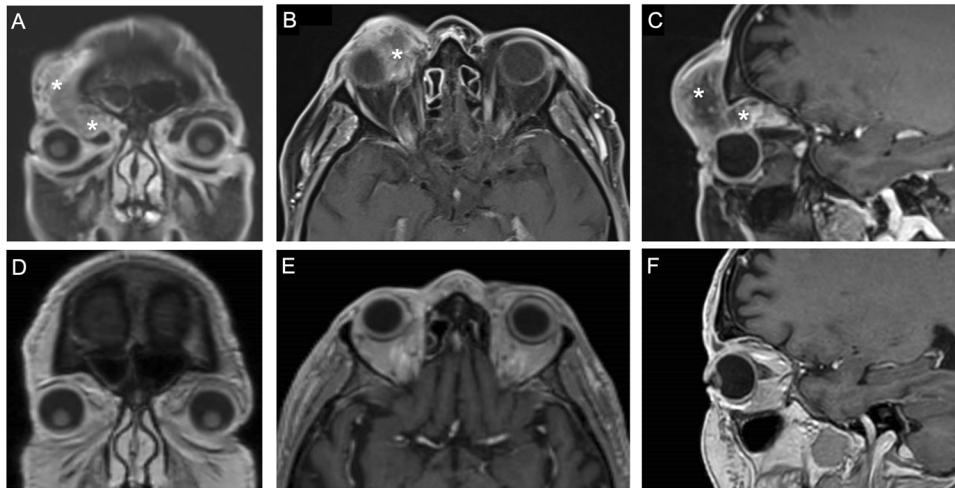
MRI scans of an 82-year-old man with squamous cell carcinoma with orbital involvement. A Before treatment; post-contrast coronal T1 fat-saturated image showing an ill-defined low enhancing mass penetrating the right orbit with globe compression. B Before treatment; post-contrast axial T1 fat-saturated image showing an ill-defined low enhancing mass penetrating the right orbit. C Before treatment; post-contrast sagittal T1 fat-saturated image showing an ill-defined low enhancing mass extending from the right forehead to the left orbit, advancing along the orbital and penetrating the right orbit. D After treatment; post-contrast coronal T1 image showing a complete response. E After treatment; post-contrast axial T1 image showing a complete response. F After treatment; post-contrast sagittal T1 image, showing a complete response. *indicates the tumor before treatment.
